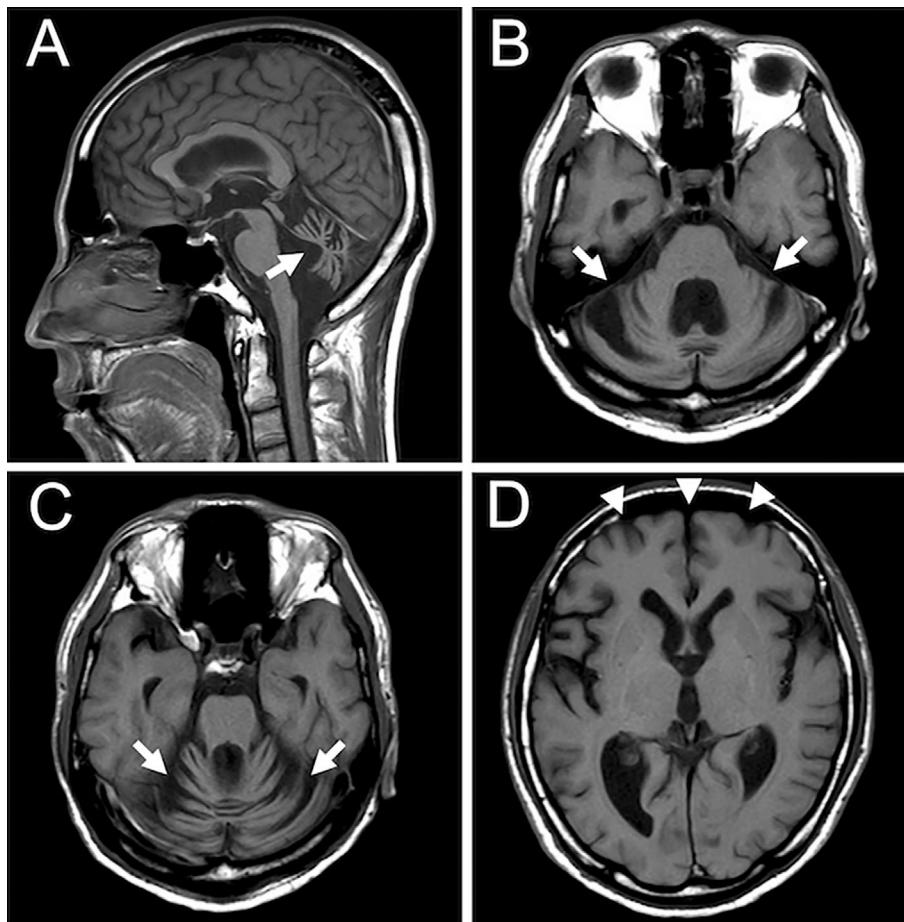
Magnetic resonance imaging of the brain. All images are T1-weighted images. Mid-sagittal (A) and axial (B, C) images show marked cerebellar atrophy (arrows). Mild atrophy is observed in the frontal lobes (D, arrowheads).
